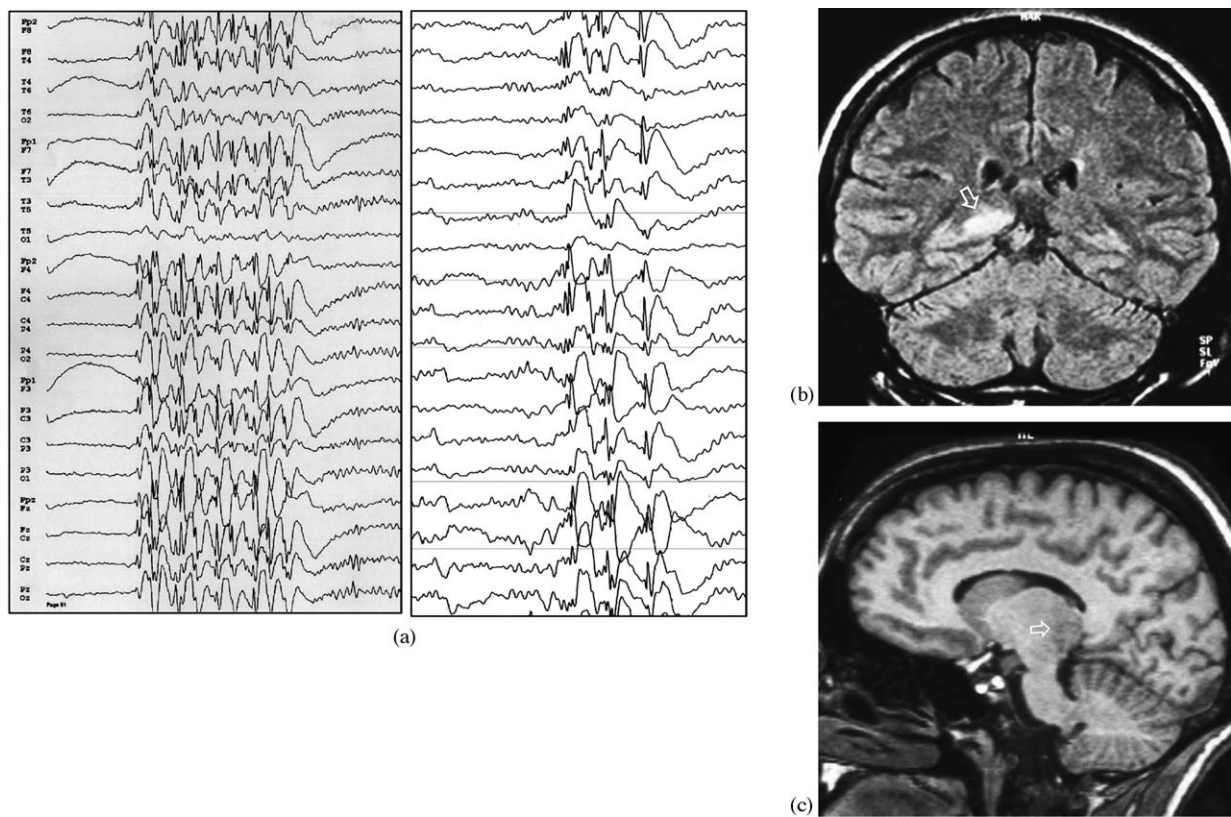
Patient 3: (a) EEG: generalized PSW pattern; (b) coronal FLAIR MRI; (c) sagittal T1 weighted MRI: tumor involving the infero-mediodorsal part of the right thalamus (arrows).
